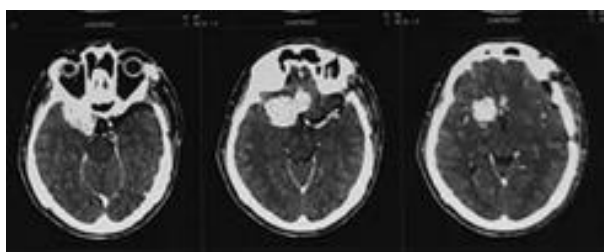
Preoperative images CT brain with contrast before second stage surgery.
